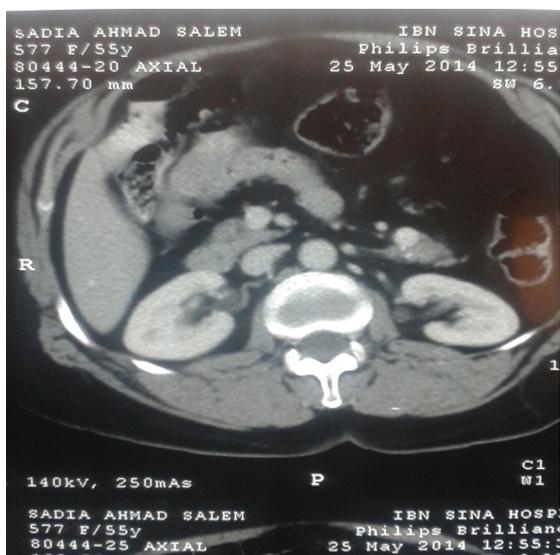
CT scan image at level of upper abdomen, showed absence of spleen at its usual site in the left hypochondrial region.
